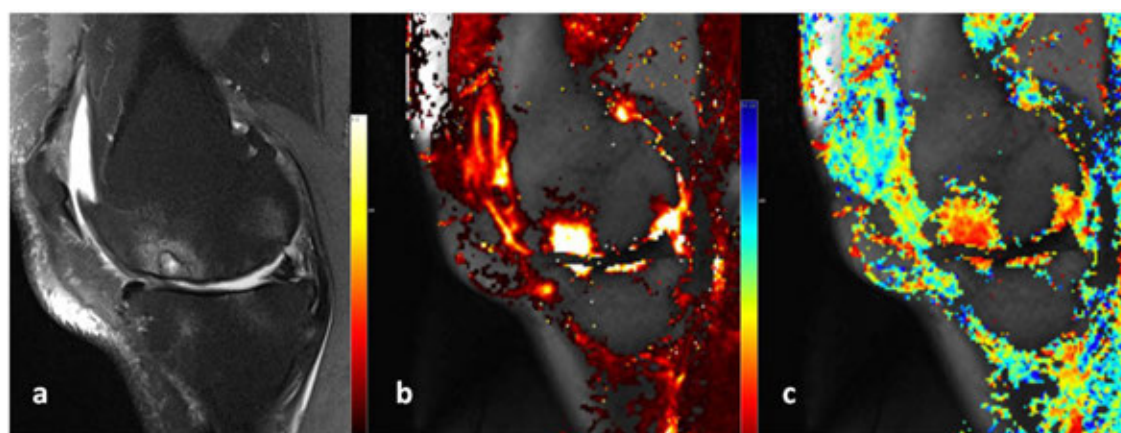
Bone marrow lesion with cyst in knee with OA. a) non-CE-MRI b) DCE-MRI Initial rate of enhancement (IRE) c) DCE-MRI Time To Peak (TTP).
